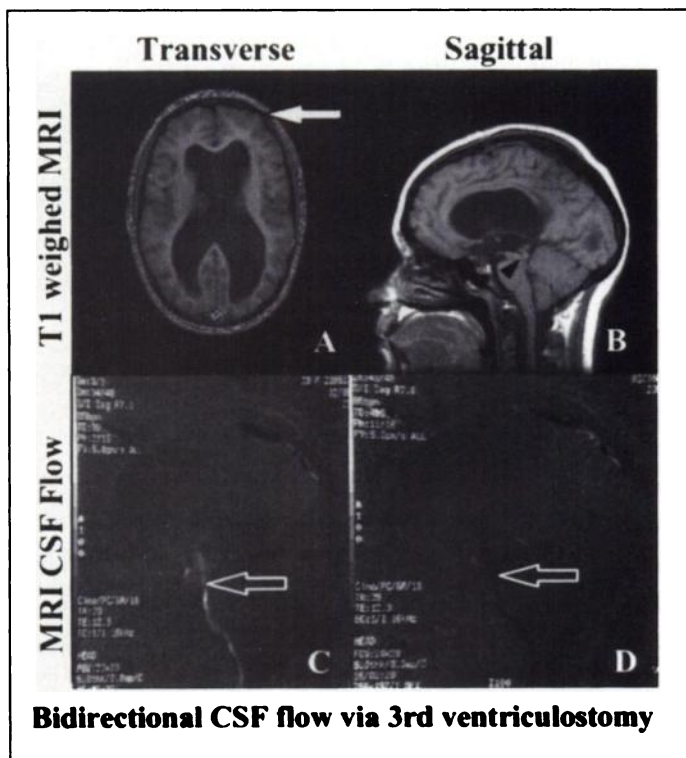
(A) Transverse and (B) sagittal T1-weighted MRI images, in a patient with hydrocephalus due to aqueductal stenosis (arrow head), show dilatation of ventricular system. Note the left frontal region shows no remarkable structural changes (solid arrow). (C, D) The CSF flow study after neuroendoscopic third ventriculostomy shows bidirectional CSF flow indicating patent ventriculostomy.
